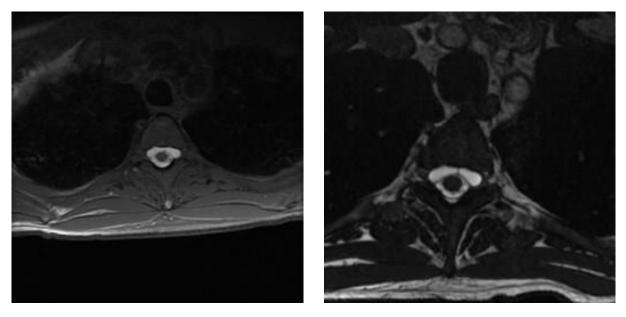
T1-weighted MRI with intrathecal Gd-DTPA (left); fast-imaging employing steady-state acquisition (FIESTA) MRI (right). Fluid exhibiting high signal intensity is seen anterior to the medulla.
